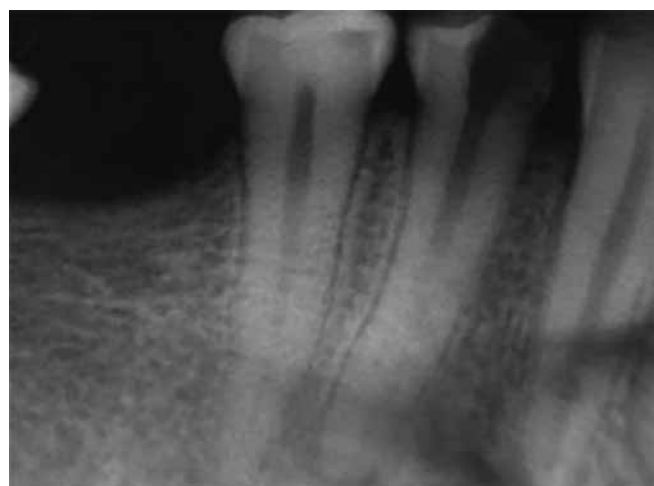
Initial radiograph, showing the possible existence of three canals in one root
